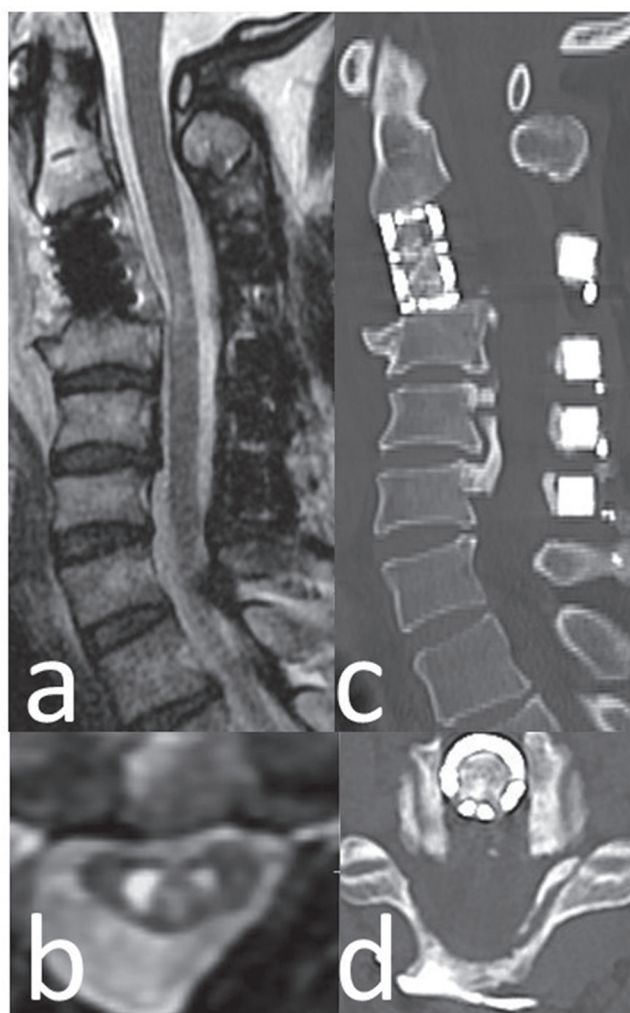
a, b: Postoperative magnetic resonance images showing adequate decompression of the spinal cord at the C3–4 level. c, d: Postoperative computed tomography showing C3 vertebrectomy and fusion with mesh cages filled with local bone. The C2–4 local kyphotic angle had improved from 25 degrees to 18 degrees in the straight position.
